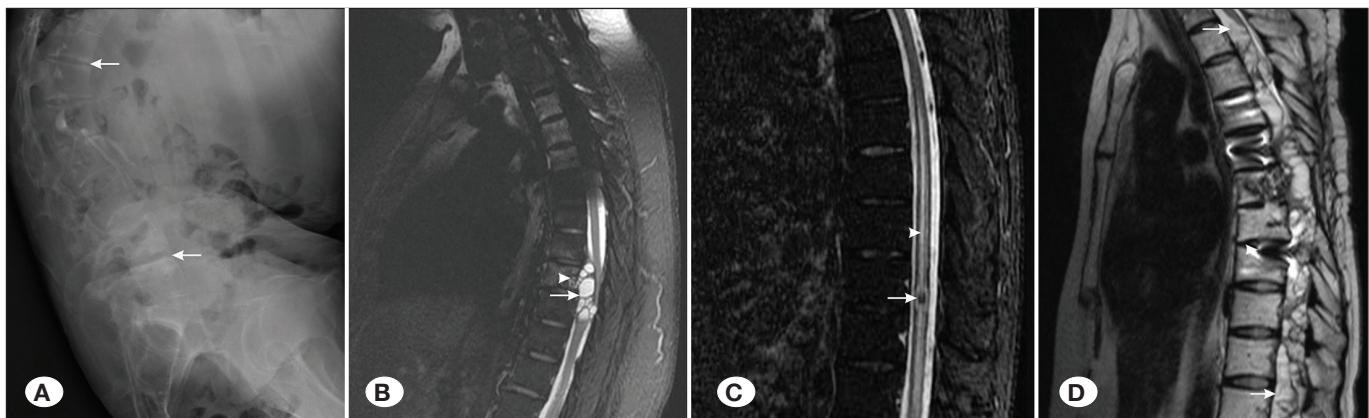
Spinal hydatidosis. A) End-plate osteochondritis and spinal deformity of the lumbar vertebrae on plain radiographs (arrows), B) Typical T2-weighted MR image of paravertebral-extradural hydatidosis (arrows), C) T2-weighted MR image of intramedullary hydatidosis (arrow) and the surrounding edema (arrowhead), D) T2-weighted MR image of intramedullary disseminated hydatidosis after surgery (arrows) and original fixation (arrowhead).
